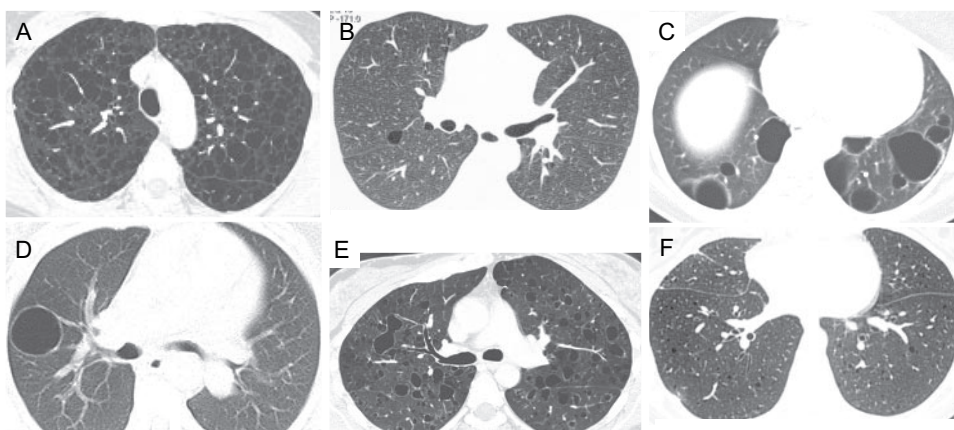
HRCT scans of cystic lung diseases that can mimic LAM. *Top left, A:* LAM cysts are typically round or ovoid, 2 to 5 mm in diameter, and surrounded by healthy lung, but may become large (25 to 30 mm) and polygonal with more severe involvement. *Top center, B:* BHD thin-walled cysts that have a subpleural predilection are shown. *Top right, C:* follicular bronchiolitis; round thin-walled cysts 3 to 12 mm in diameter are thought to represent dilated distal airspaces. *Bottom left, D:* light-chain deposition disease HRCT scan manifestations commonly include nodules, lymphadenopathy, and cysts, which are also believed to represent dilated small airways. *Bottom center, E:* pulmonary LCH; the presence of irregular, bizarrely shaped cysts with intermediate wall thickness, and cysts with nodules and sparing of the costophrenic angles help to distinguish pulmonary LCH from LAM. *Bottom right, F:* metastatic endometrial cell sarcoma; thin-walled cysts such as these can also be associated with synovial cell sarcoma and leiomyosarcoma.
